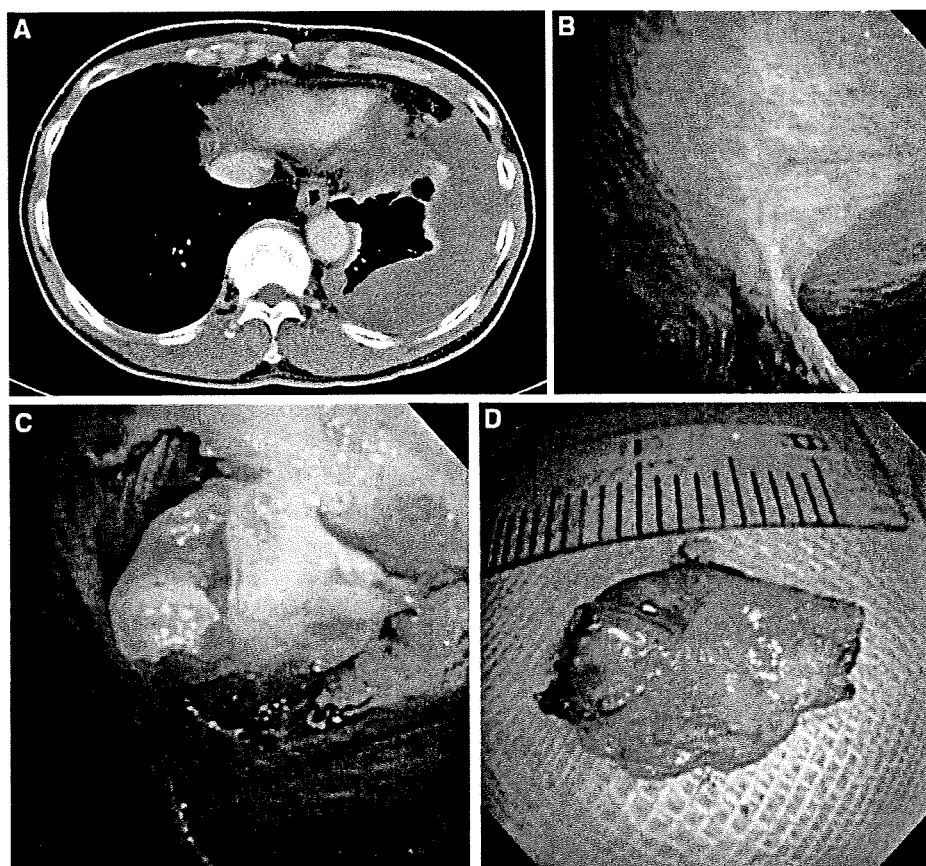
Electrocautery pleural biopsy using IT knife in case 3. A Chest computed tomography indicated pleural effusion and thickened parietal pleura on the left side. B Whitish, thickened parietal pleura with smooth pleural surface observed endoscopically. C After an
